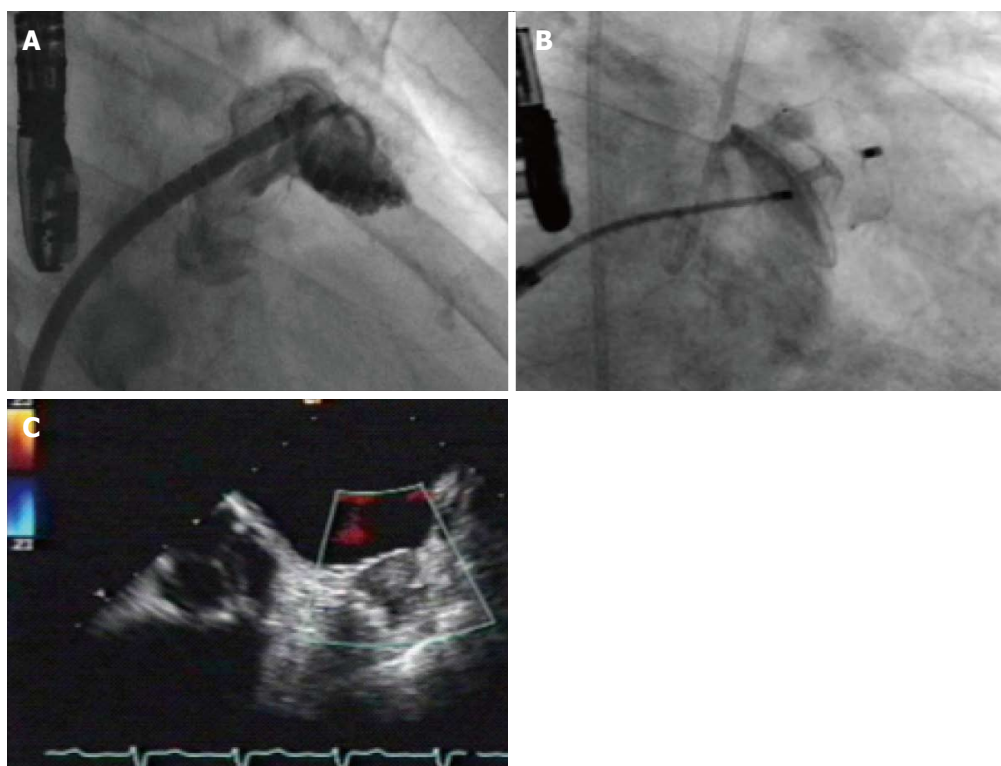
Measurement of left atrial appendage (A), implantation of an Amulet device (B) and postinterventional transesophageal echocardiogram revealing good sealing without any leak (C).
